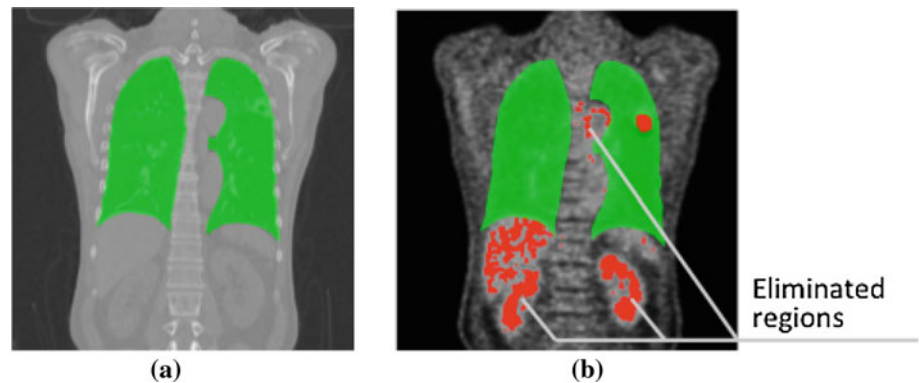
FP reduction. Lung regions were isolated by CT (a), and FP reduction was thus achieved (b)
